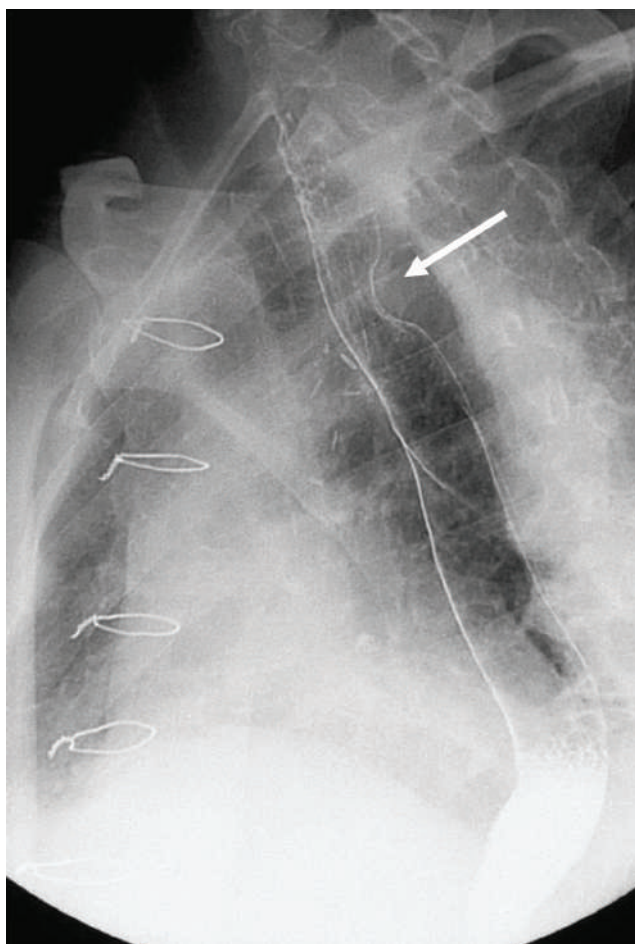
X-ray of the chest organs in lateral projection. The aberrant right subclavian artery (arteria lusoria) deflects the contrasted esophagus, shown by the arrow. Made by the doctor Kemezh Yu.V.
